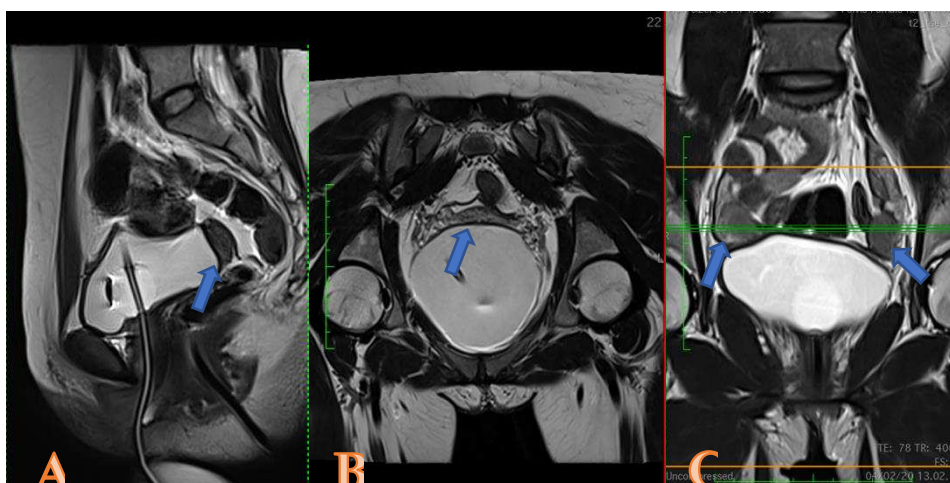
a 29-year-old female patient with MRKH type I. (a) sagittal MRI T2 showing midline triangular soft tissue without cavities, (b) axial MRI T2 showing isointense fibrous band (c) coronal MRI T2 showing bilateral hyperintense rudimentary uterine remnants
